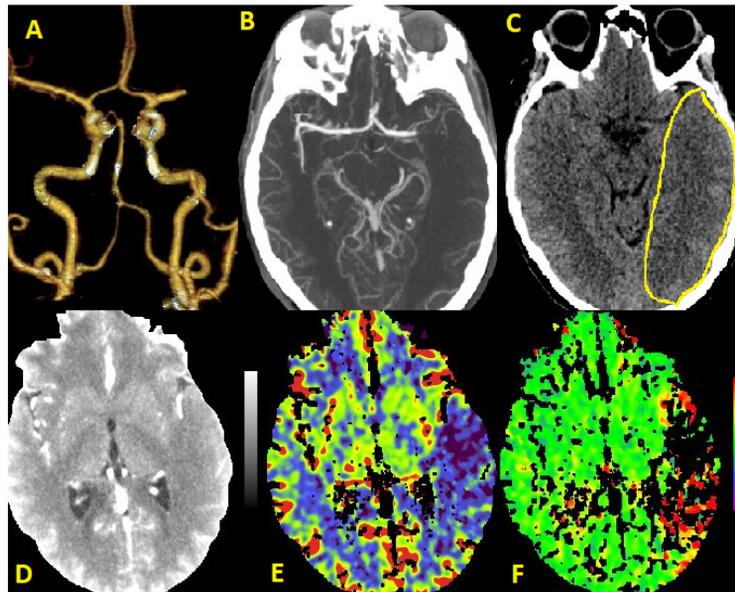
Imaging performed at baseline. (A) CT angiogram of cerebral arteries with reconstruction and (B) CT angiogram showing total occlusion of the distal M1 segment of the left MCA. (C) CT scan of brain showing faint hypodensity involving the cortical and subcortical areas of the left temporoparietal lobes, left insular, subcortical and left external capsule with early signs of sulcal effacement. (D) CT perfusion (E) Cerebral blood volume (CBV) map, (F) Time to peak (TTP) maps showing perfusion deficit in left temporoparietal lobes, denoting an infarct core with a significantly large penumbra involving the left frontoparietotemporo and occipital lobes.
